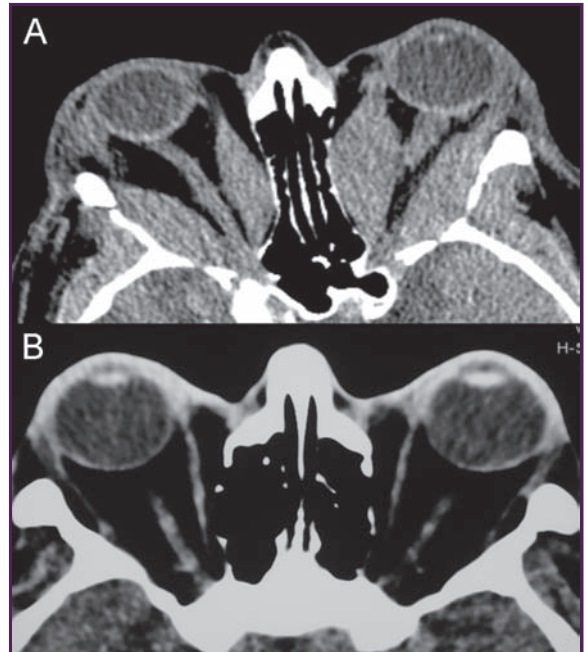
(A) Diffuse, symmetric, tendon-sparing extraocular muscles enlargement in axial CT scan of the orbits. (B) Symmetric severe proptosis, straightening of optic nerves with mainly enlargement of fat compartment and minimal muscle involvement often seen in young female patients with TED who are typically non-smokers.
